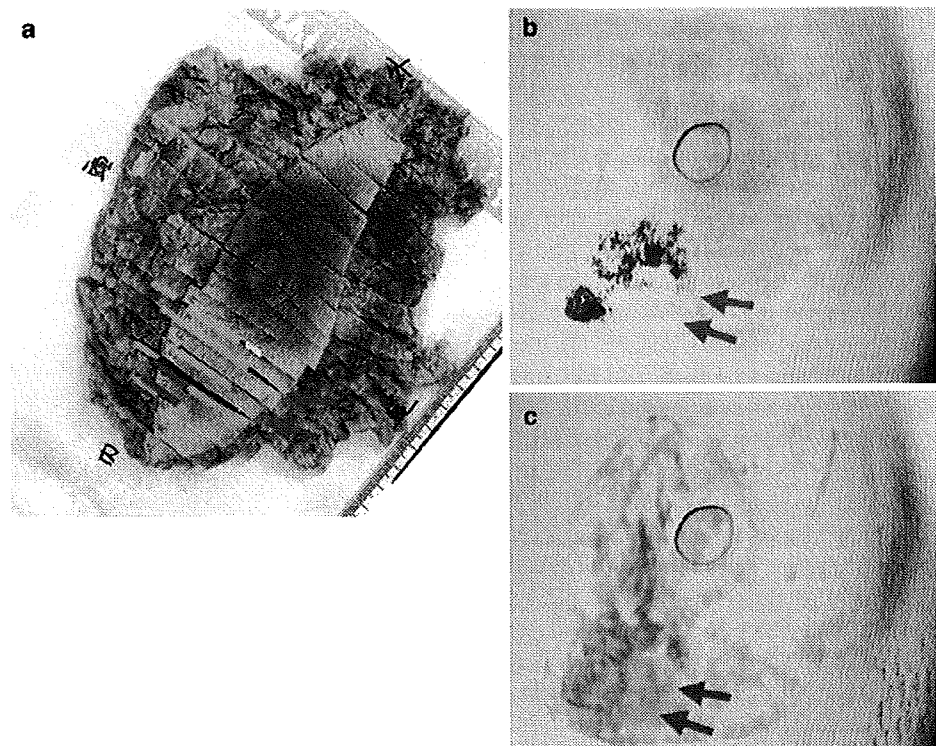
A 44-year-old woman with invasive ductal carcinoma of the breast. a Panoramic view of the tumor in the resected tissues. b CT image in the early-enhancement phase. Tumor tissues extending to the left from the main tumor are not depicted. c Perfusion map image. The tumor tissues (including the tumor on the left side that could not be visualized in the early-enhancement phase) are clearly depicted (pink arrow), showing good agreement with the pathology findings
